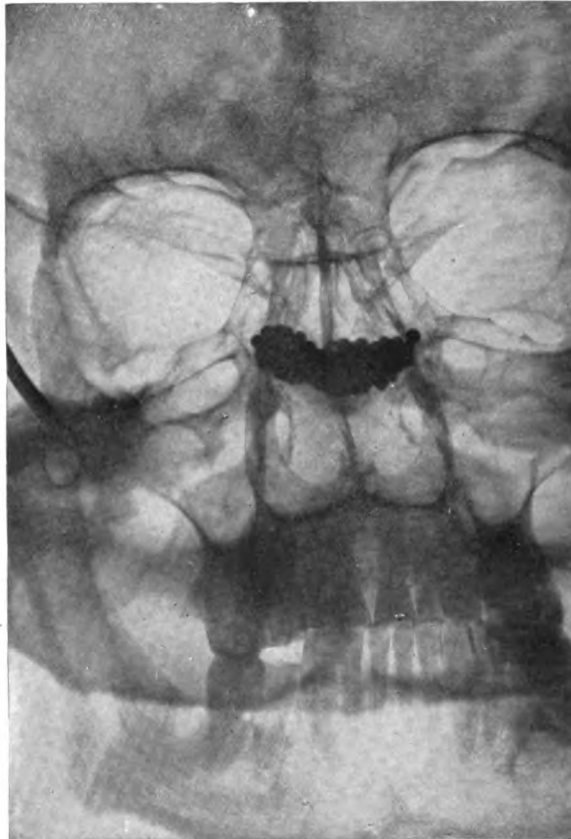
Anteroposterior radiograph of the sphenoid cells full of lead in empty skull.
